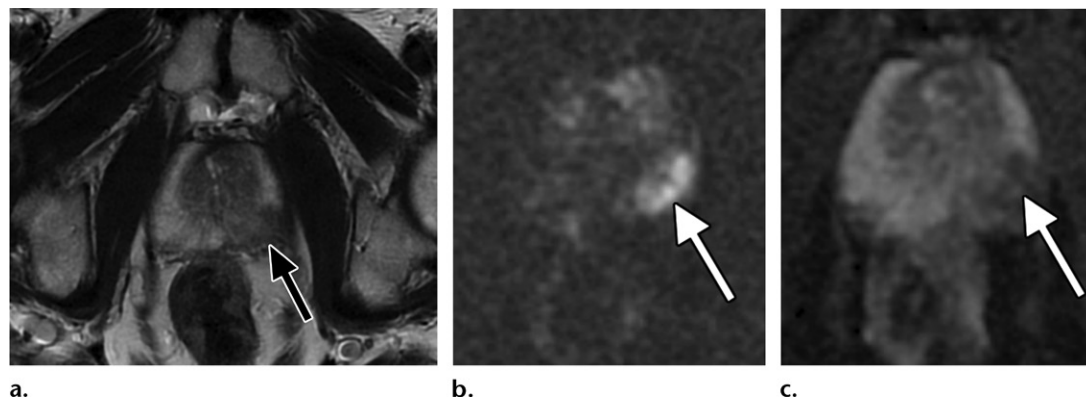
Biopsy-proven prostate cancer in a 68-year-old man. (a) Axial T2-weighted MR image obtained with the PROPELLER (periodically rotated overlapping parallel lines with enhanced reconstruction) sequence shows a 19-mm hypointense lesion (arrow) in the left peripheral zone, extending from the apex of the prostate gland to mid gland. The indistinctness of the capsule is suggestive of an extraprostatic extension. (b, c) Axial diffusion-weighted MR image ($b = 2000 \text{ sec/mm}^2$) (b) and apparent diffusion coefficient map (c) show associated restricted diffusion (Prostate Imaging Reporting and Data System [PI-RADS] category 5) (arrow). (Case courtesy of Amirkasra Mojtahed, MD, Massachusetts General Hospital, Boston, Mass.)
